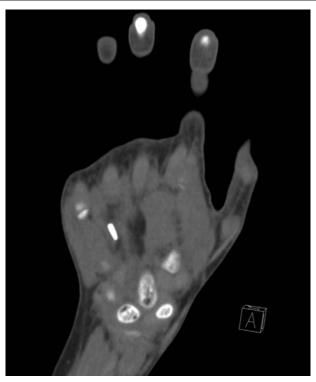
Hand CT showing a radiopaque foreign body in the soft tissue of the palmar aspect at the 4th metacarpal (red circle).
